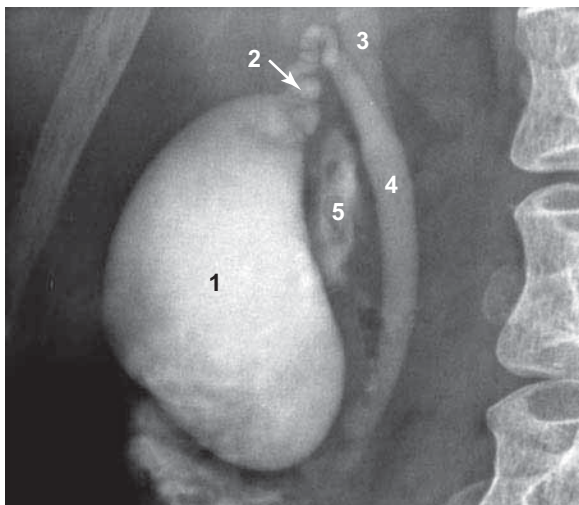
Radiograph of Gallbladder and Biliary Ducts
